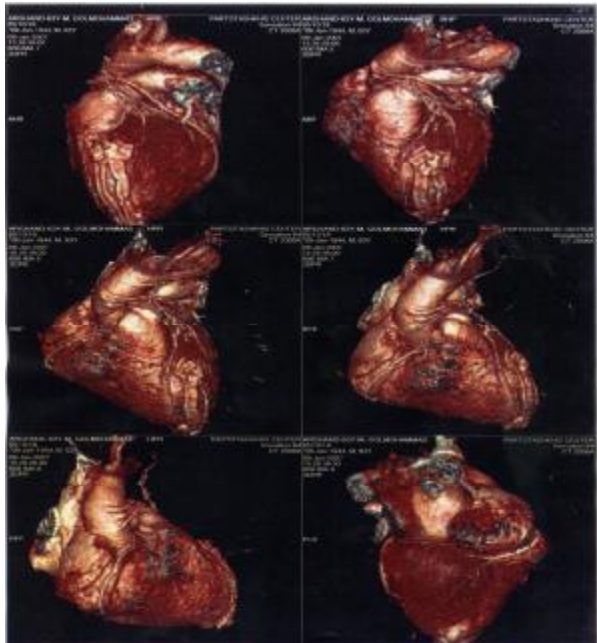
CT-Angiography in one of our patients 7 years after 4 graft CABG and LV aneurysmal plication.
